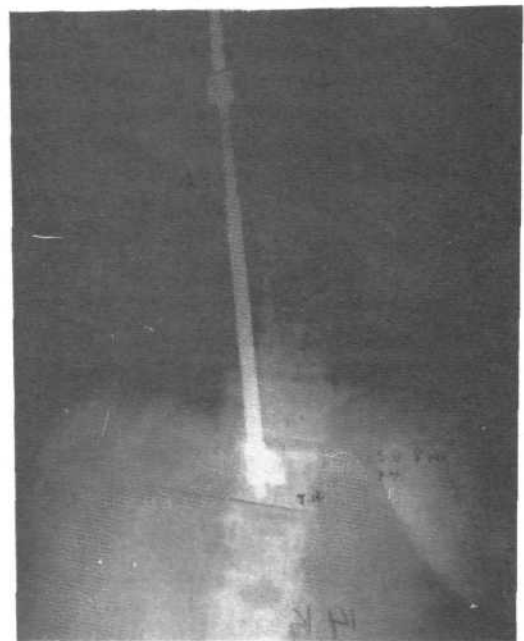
The post-operative roentgenograms showing the resected ribs and the 30° Cobb angle.
